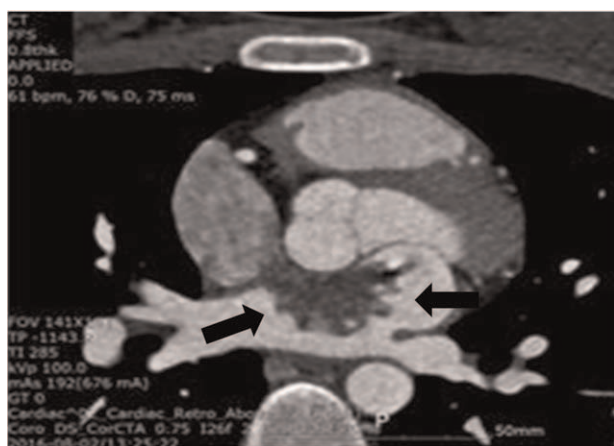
Cardiac computed tomography revealed an enhanced mass measuring 3 cm × 2.2 cm × 3 cm with an irregular margin on the anterior wall of the left atrium and the border of the fossa ovalis.
